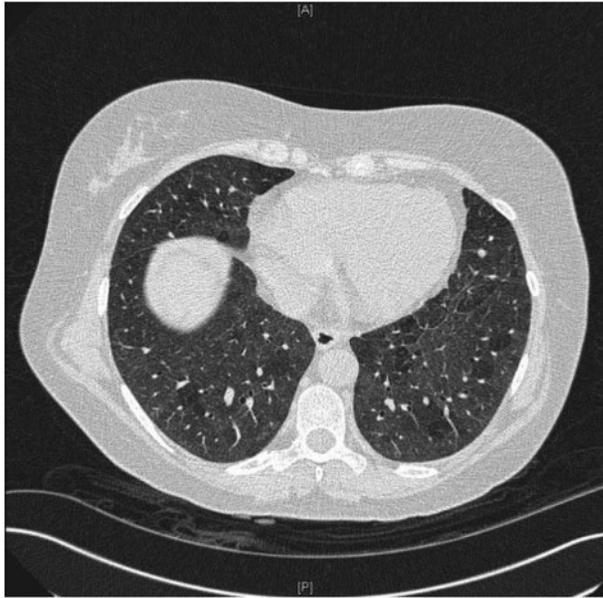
HRCT showing minor air trapping and mild ground glass change in the lower lobes bilaterally.
